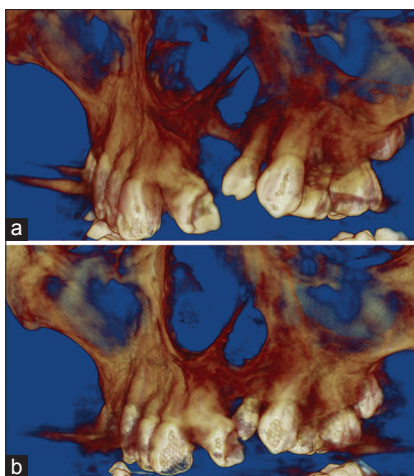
Sectional cone-beam computed tomography of a patient who underwent nasoalveolar molding and gingivoperiosteoplasty surgery to repair the alveolus at the time of primary lip closure. Note good bone formation on the right former cleft side. This patient did not need secondary alveolar bone graft surgery
